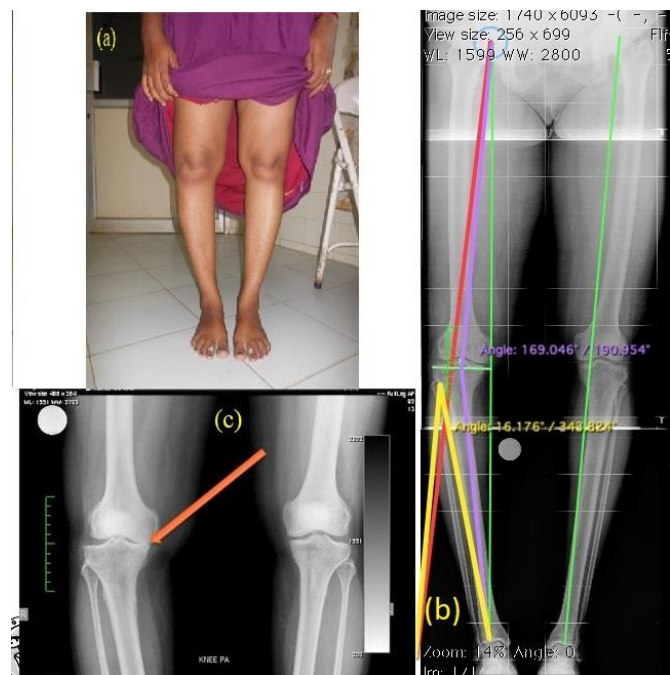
(a) Clinical photograph - varus deformity of right knee. (b) Malalignment test was done on a long leg film. Following were the angles calculated: Medial proximal tibial angle (MPTA)-82°, Lateral distal tibial angle (LDFTA)-81°, Joint line congruence angle JICA-4° and Tibio-femoral angle-169°. Correction planned was 16° to achieve a 5° postoperative valgus. (c) Standing antero-posterior radiograph of knee - narrowed medial joint space (Red arrow), subchondral sclerosis and mild lateral subluxation of tibia.
